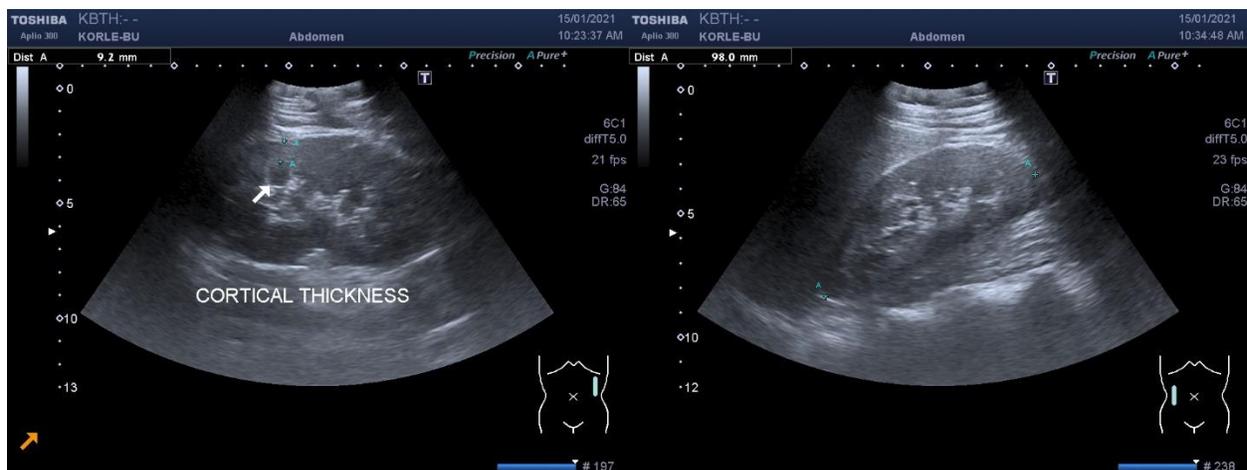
Longitudinal greyscale ultrasound showing A. measurement of left RCT over a renal pyramid (white arrow) denoted by callipers A-A and B. measurement of right BPL denoted by callipers A-A.
